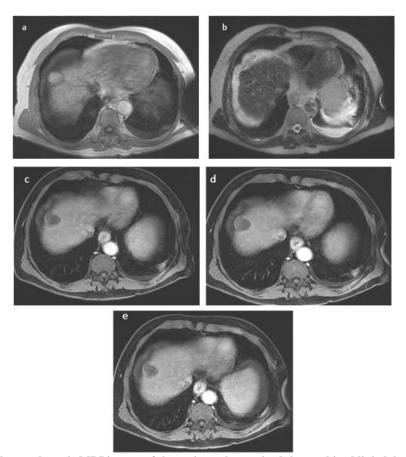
2-month follow-up hepatic MRI images of the patient who received the combined lipiodolated chemoembolization and radiofrequency treatment showing the totally devascularized liver dome lesion, in T1 hypersignal (a), T2 hyposignal (b), without vascular enhancement at the arterial phase (c) nor wash out at the portal and delayed phase(d,e), This is a complete response according to the m-RECIST criteria
